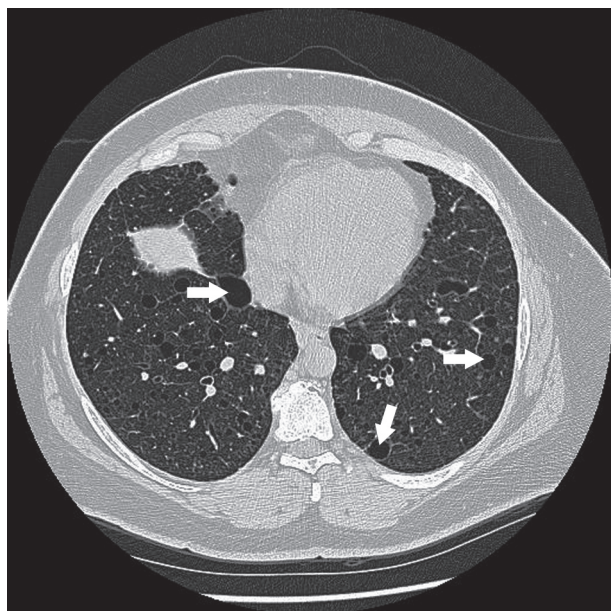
High-resolution computed tomography demonstrated multiple, irregular, thin-walled cysts arranged randomly in both lungs consistent with lymphangioliomyomatosis.
